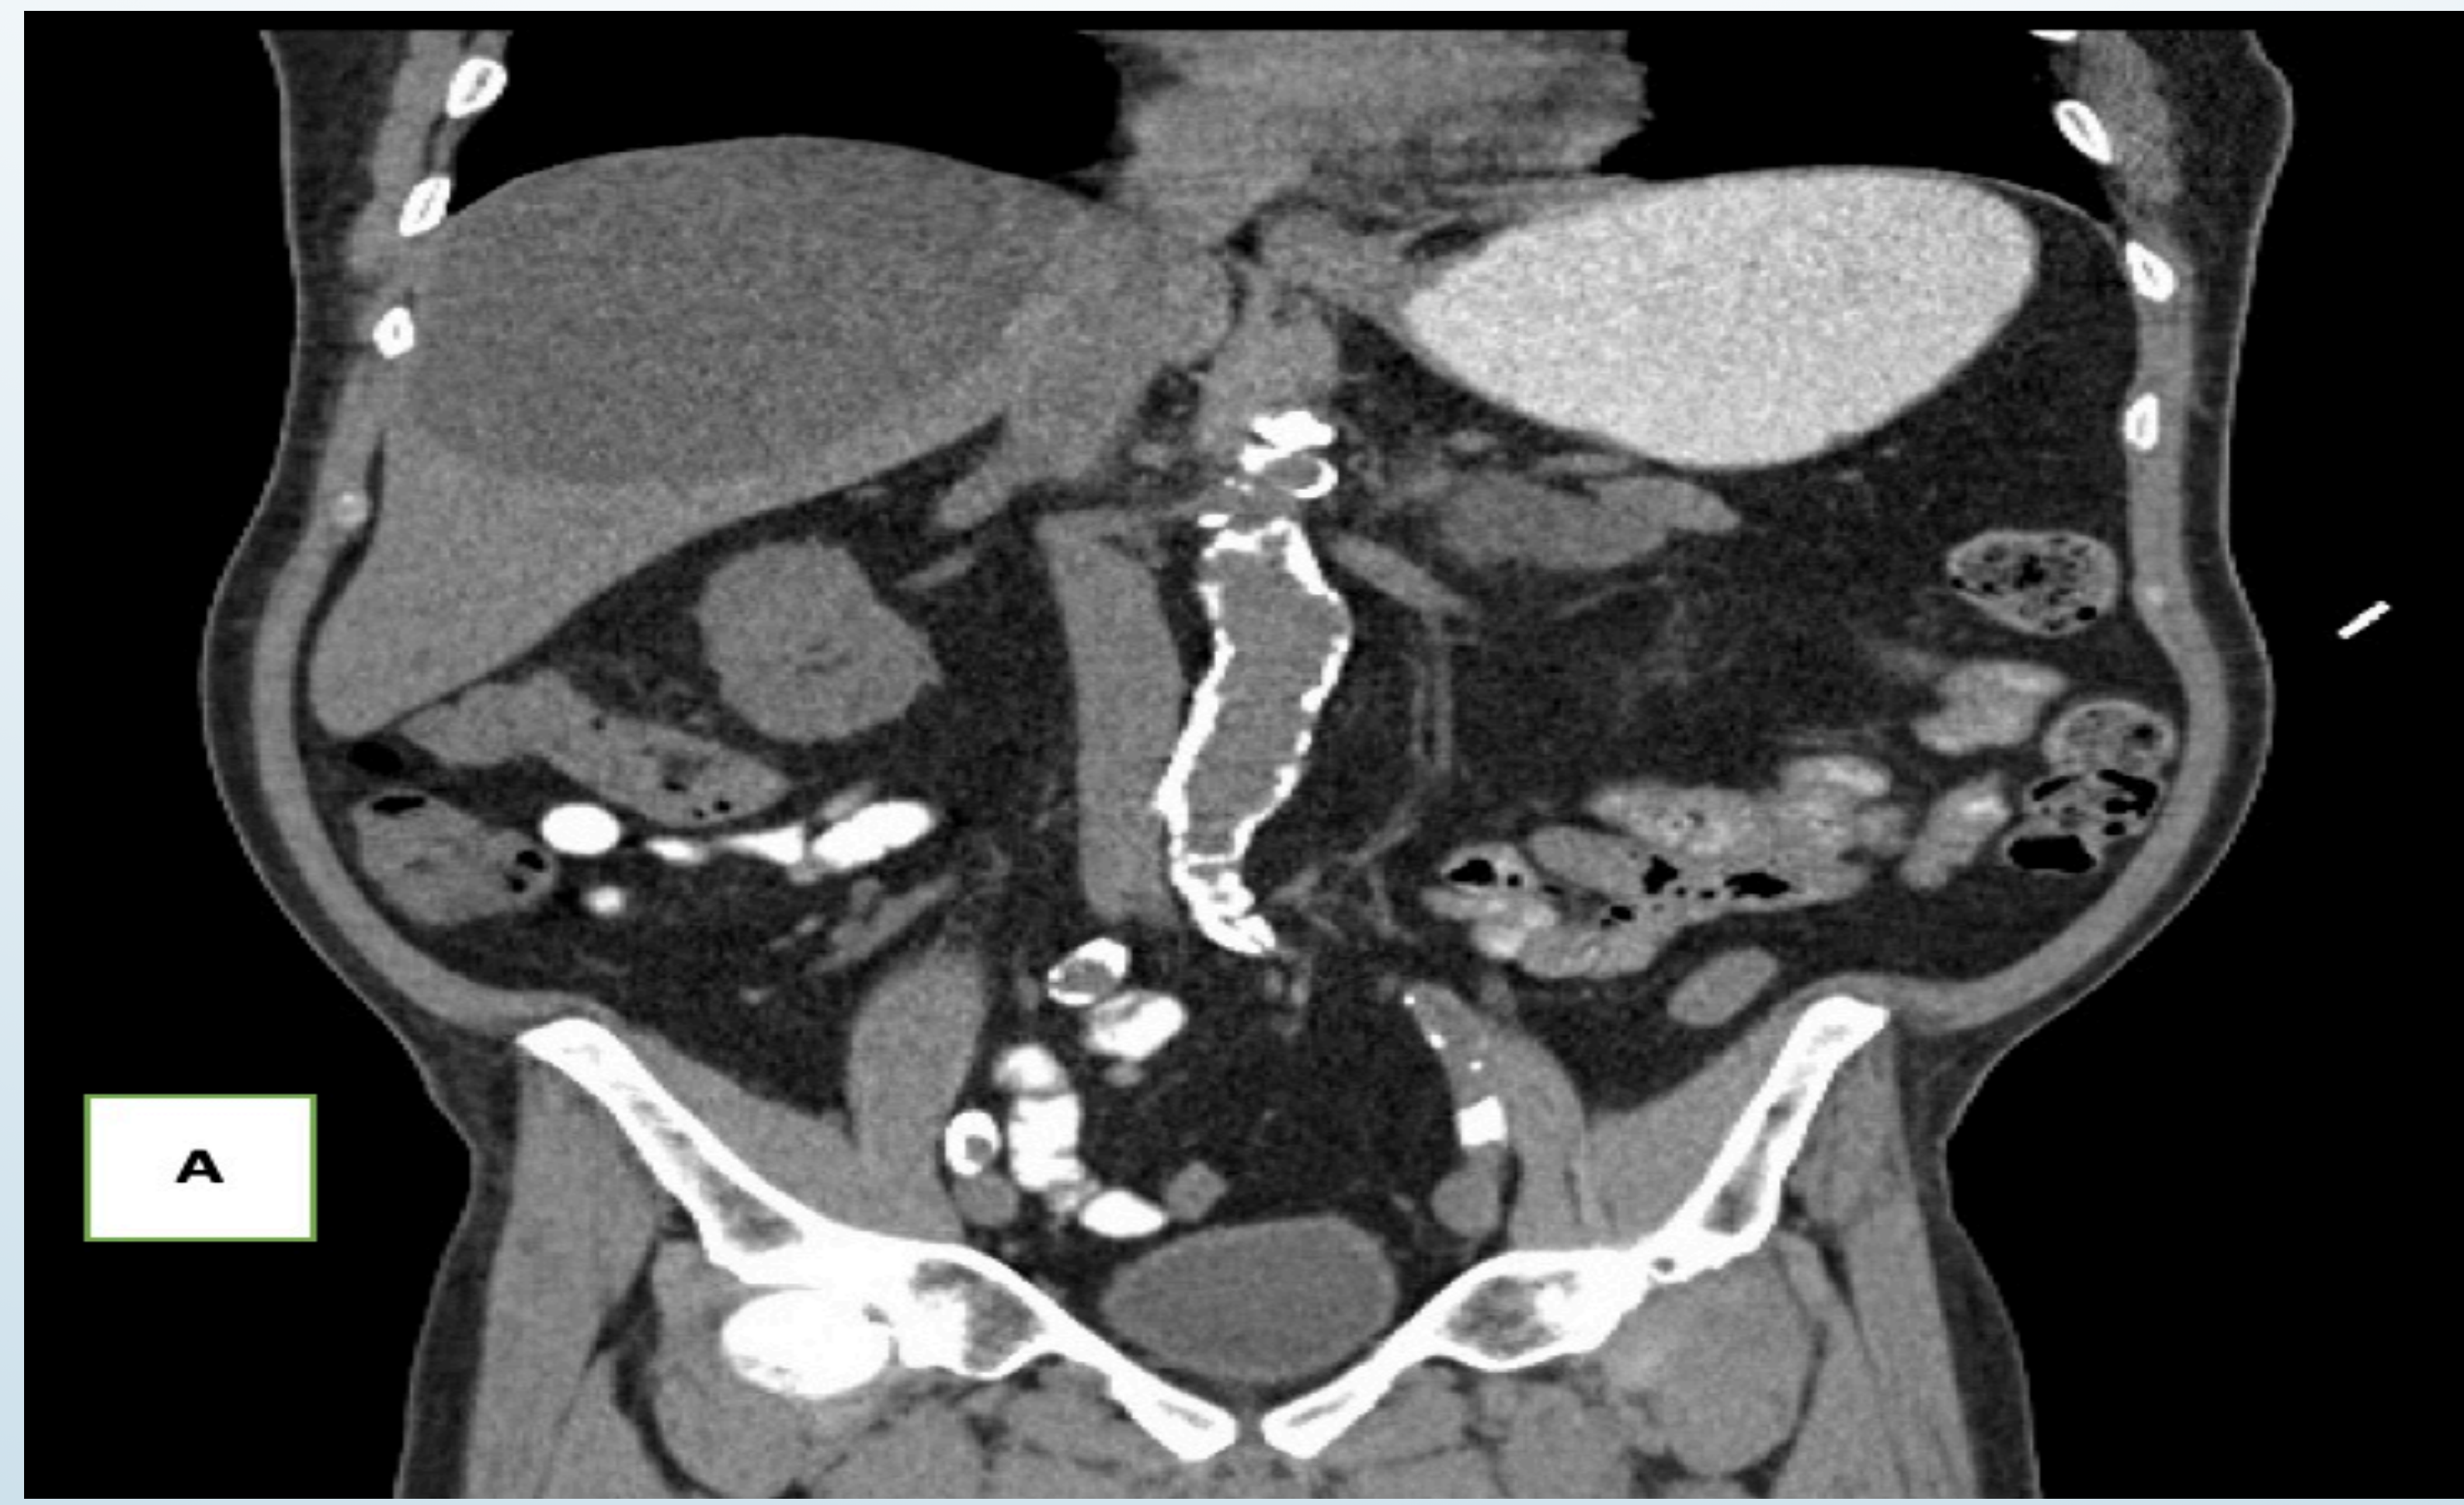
CT Abdomen from 2014 showing a benign right sided hepatic cyst
